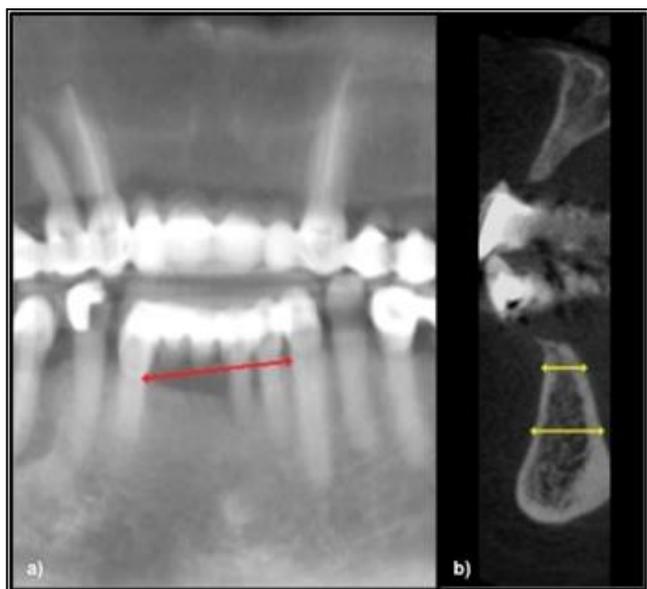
Initial CBCT. a) Measurement of 16.67 mm horizontally, b) Measurement of 5.82mm in the coronal part of the edentulous zone defect.
